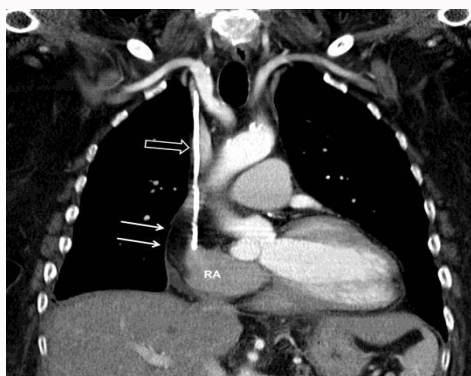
Coronal oblique reformatted CT image shows catheter (open arrow) terminating in the right atrium. Circumferential fat density tissue (arrows) narrows the superior vena cava lumen and extends along the lateral wall of the right atrium.
